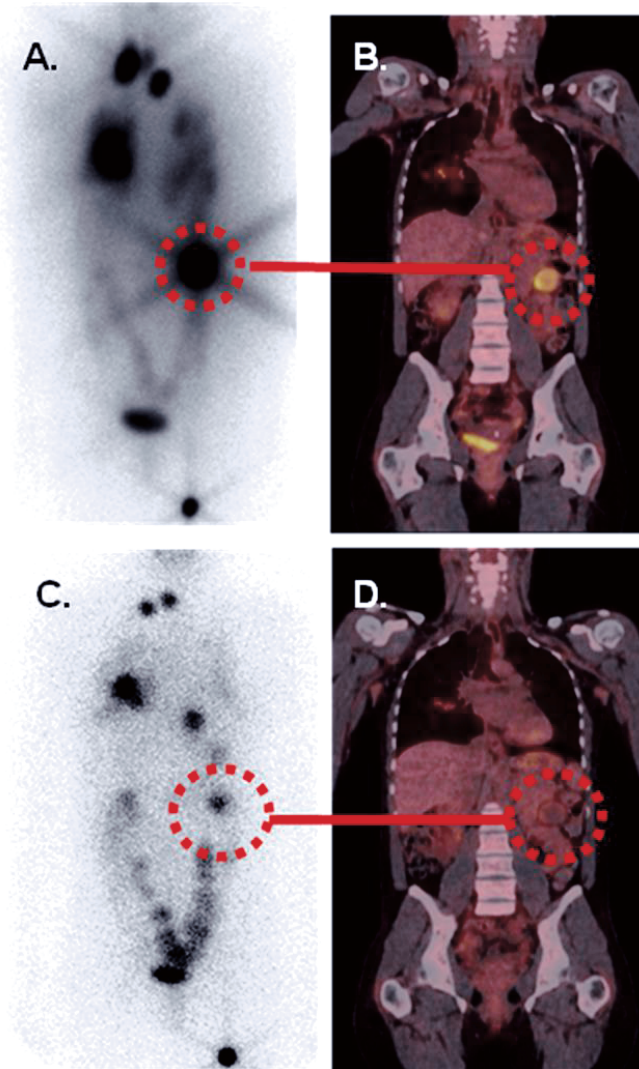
Young female with metastatic PTC. FDG PET/CT was performed on the same day but before a therapeutic radioiodine dosage was given after stimulation with recombinant human TSH (rhTSH). A: Planar post-therapy radioiodine scan: intense radioiodine uptake in numerous metastases in the neck, lungs, left kidney, and in the left thigh. Physiological intestinal accumulation and urinary tract excretion of FDG. B: Coronal FDG PET/CT image: the metastases to the the left kidney (encircled), neck, most of the lung metastases, and the metastasis to left thigh showed intense uptake of both radioiodine and FDG. C: Second planar post-therapy scan 6 months later. The radioiodine uptake in all the radioiodine avid lesions has decreased. D: Coronal FDG PET/CT image before the second therapeutic radioiodine dosage. All lesions with previously intense uptake of both radioiodine and FDG showed nearly resolved uptake. The lesion in the left kidney is encircled in the figure. Intense uptake of both FDG and radioiodine may predict good response to radioiodine.
